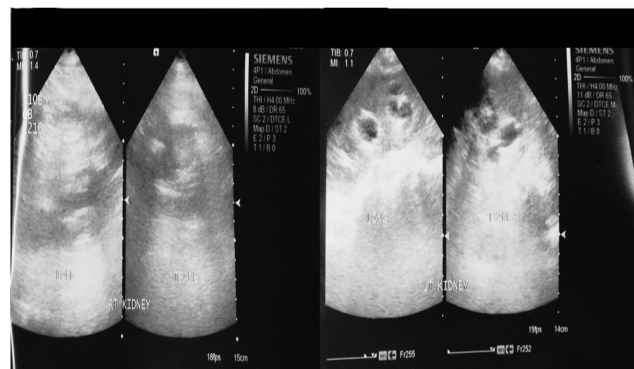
Ultrasound of the right and left kidneys with diffuse parenchymal changes and Grade 3-4 hydronephrosis.
